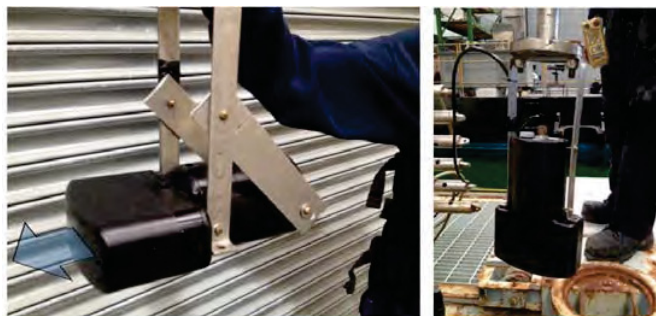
The Teledyne BlueView P450-45 sonar head [8]. Two mounting positions were used for anechoic ultrasonic field measurements: horizontal mounting (left) for far-field measurements (beyond 2 m from the sonar face), and vertical mounting (right) for near-field.. The sonar beam direction (axis) is indicated by the arrow.
